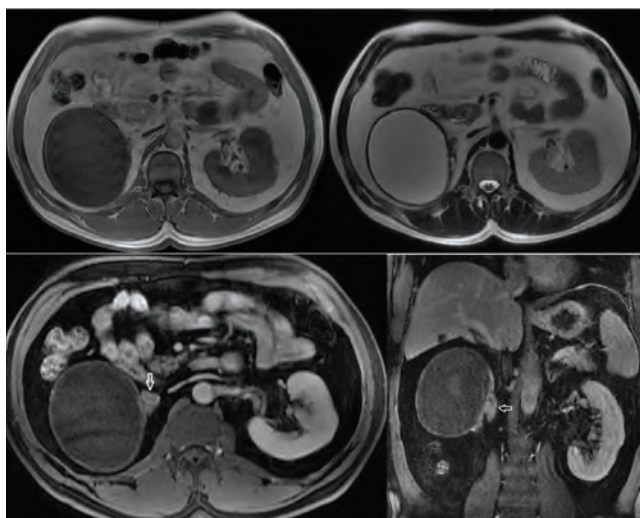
Axial T1 (a) and T2 (b) weighted MR images reveal lack of hemorrhage and debris within the cyst. Axial (c) and coronal (d) post-contrast fat saturated T1 weighted MR images demonstrate contrast enhancement adjacent to the cyst compatible with atrophic right kidney (arrows). The extension of the cyst indicates subcapsular origin (a-d).
